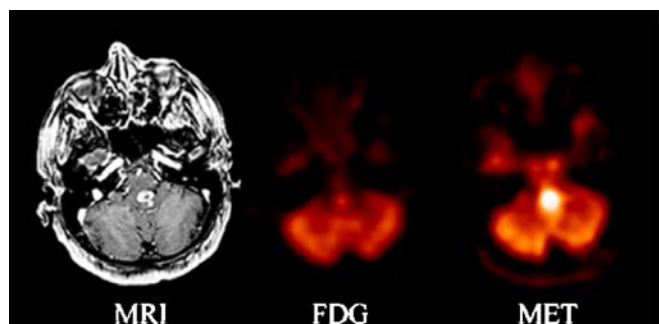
Grade III glioma. Patient with anaplastic astrocytoma with negligible FDG uptake but high methionine uptake. There is variable glucose uptake in grade III astrocytomas, some even show very high glucose uptake.
